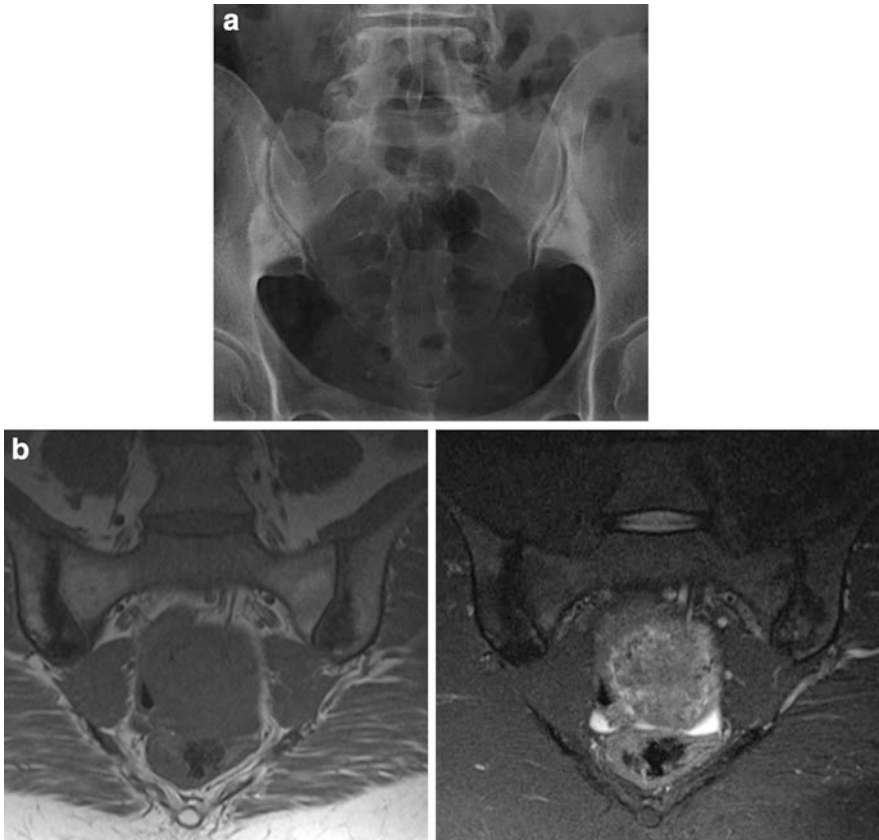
(a) Frontal radiograph showing osteitis condensans ilii. Typical bilateral triangular sclerosis in the ilium adjacent to the sacroiliac joints is depicted. There are no features of erosions or ankylosis. (b) MRI showing osteitis condensans ilii. Coronal T1 and STIR images demonstrate
